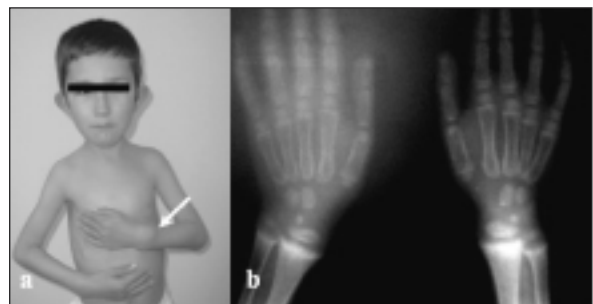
(a) The expansion of the wrists due to rickets, (b) Bilateral widened, concave and frayed epiphyses of radius and ulna on radiography.
